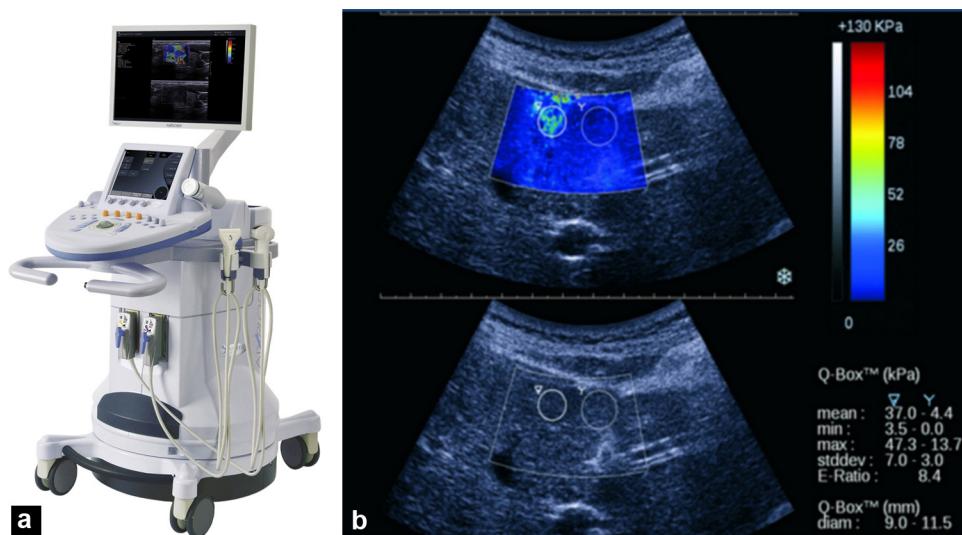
Shear Wave elastography: a: ultrasound diagnostic imaging device onto which Shear Wave elastography software has been implemented; b: example of result provided by the instrument: color mapping and Qbox.
